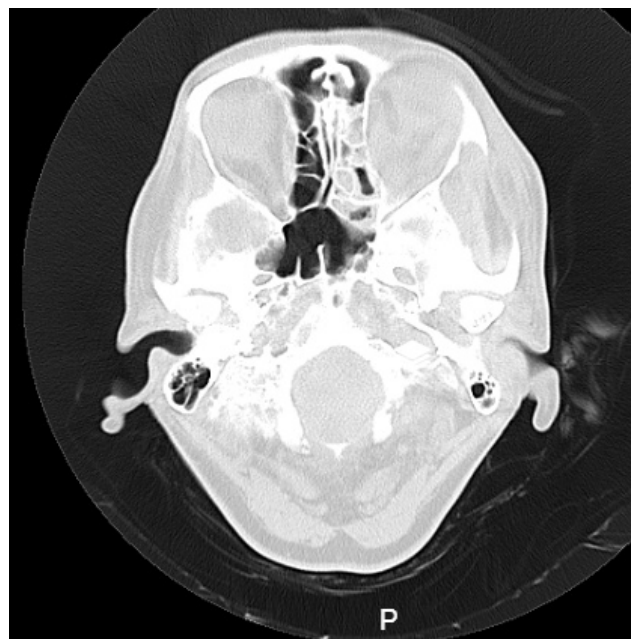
Spiral sinus CT scan: Infiltration of the left ethmoid, maxillary sinuses, and deformation of the posterior globe.
